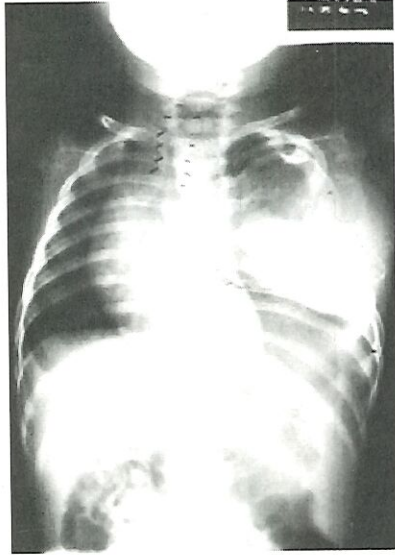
Chest x-rays revealed a large extrapulmonary mass, spreading the adjoining ribs apart. Thick irregular calcification and compression of the mediastinum to the right were also evident.
